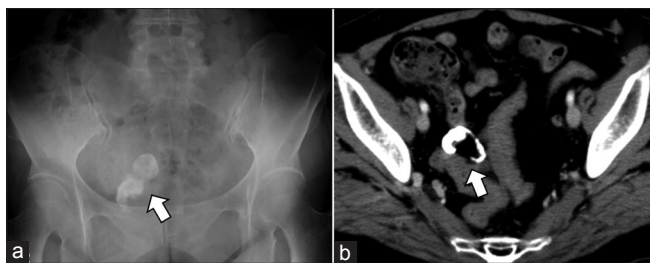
Findings of preoperative pelvic X-ray and computed tomography. Pelvic X-ray (a) and contrast-enhanced computed tomography (b) demonstrated an irregular mass with calcification in the pelvic cavity, measuring approximately 3 cm × 4 cm in diameter. The tumor was not cystic and its margins were not continuous
